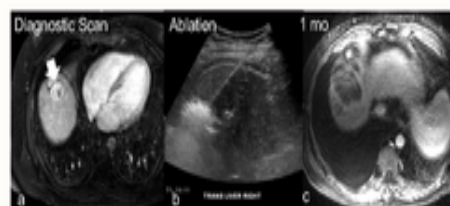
63 yo M with HCV cirrhosis (Child-Pugh B); a 3.8 cm HCC in segment 8 (arrow) and 1.0 cm HCC in segment 6 (not shown). He had BCLC stage B (intermediate) disease and underwent ultrasound-guided microwave ablation of both tumors. Fig. 4b shows the ultrasound image during the ablation. Fig. 4c shows the ablation zone on MRI at 1 month. Approximately 10 months after his ablation procedure, patient underwent liver transplantation due to his declining liver function.
